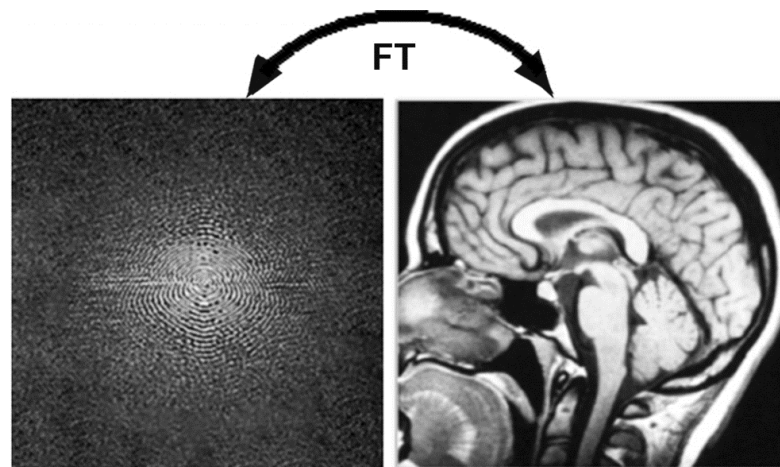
The MR image formation of a human head and its K space representation.
